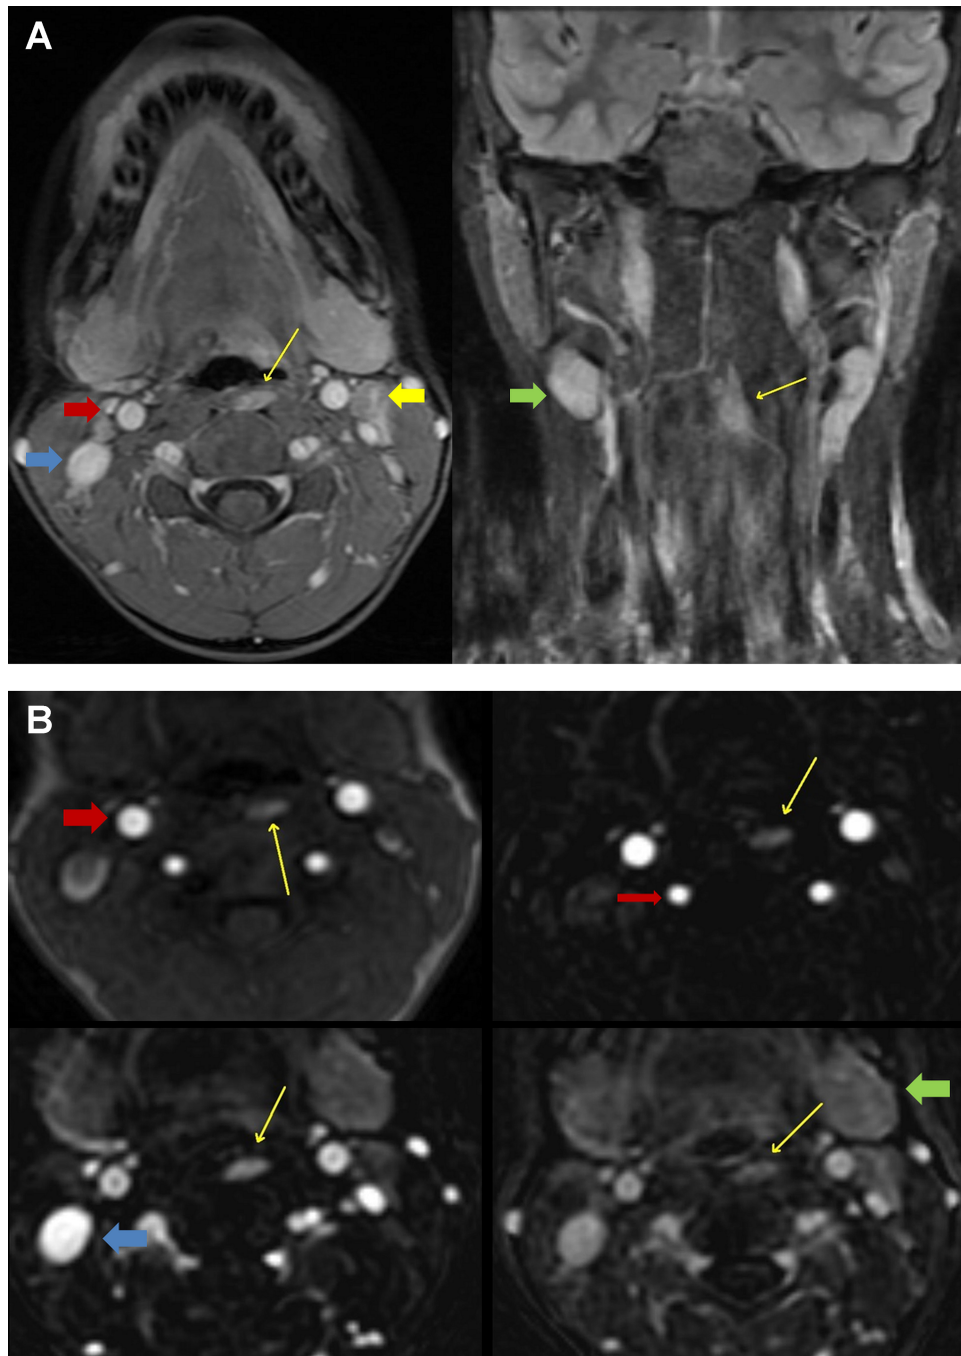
MRI with and without contrast, and perfusion imaging: (A) Axial T1 Post-contrast (left; TR: 7.8 ms, TE: 3.7 ms) and Coronal STIR (right; TR: 3050 ms, TE: 43 ms) demonstrating an oblong, enhancing area (narrow yellow arrows) in the left prevertebral soft tissues just cranial, posterior and medial to the upper pole of the left lobe of the thyroid gland (not visible on these sections of interest), that did not have MRI characteristics of vascular (red arrow = internal carotid artery; blue arrow = internal jugular vein) structures or lymph nodes (thick yellow arrow). Submandibular gland is indicated with a green arrow. (B) Magnetic Resonance Perfusion images, area of interest annotated with arrows. Top left to bottom right: early arterial (unsubtracted); early arterial, arteriovenous and late arteriovenous (subtracted) images demonstrating the enhancing area in the left prevertebral tissues that does not wash out on late perfusion images, suspicious for a parathyroid adenoma. (thick red arrow = internal carotid artery; narrow red arrow = vertebral artery; blue arrow = internal jugular vein). Submandibular gland is indicated with a green arrow. Thyroid gland is not visible on these planes of interest.
